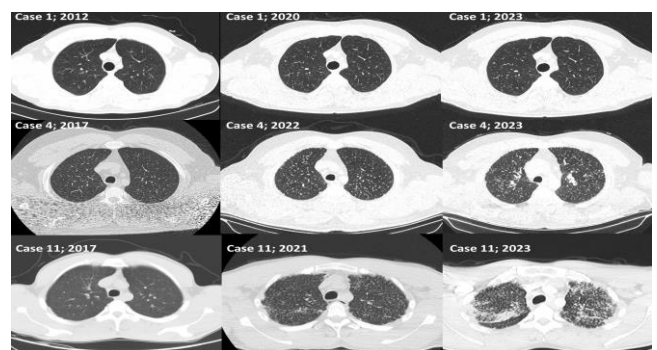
HRCT images of some pneumoconiosis cases in the follow-up
